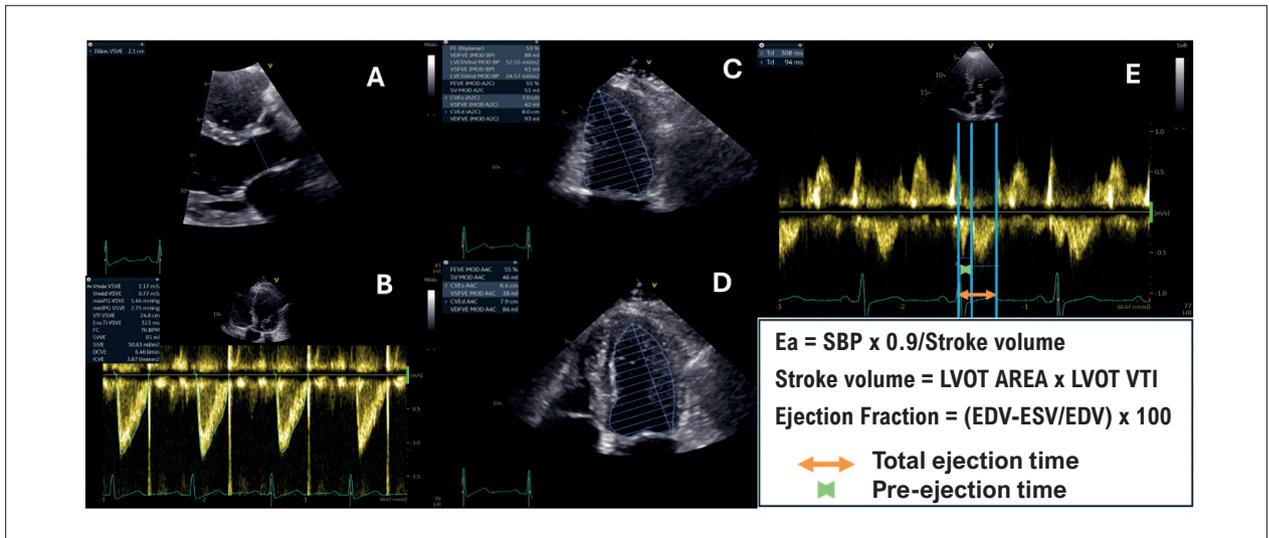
(A) Two-dimensional echocardiographic image in parasternal view, long axis, zooming in on the LV outflow tract diameter measurement. (B) VTI image of the Doppler spectrum of the LV outflow tract flow, which is obtained by tracing the fullest line of the spectrum to calculate the stroke volume. (C)/(D) Two-dimensional echocardiographic image in apical 4-chamber (D) and 2-chamber (C) views to obtain the LVEF value (Simpson method). (E) Apical 5-chamber view of the Doppler spectrum of the LV outflow tract flow and mitral inflow to obtain pre-ejection time (green) and total ejection time (orange). Ea: arterial elastance; SBP: systolic blood pressure; LVOT: left ventricular outflow tract; EDV: end-diastolic volume; ESV: end-systolic volume; VTI: velocity-time integral; LVEF: left ventricular ejection fraction.
